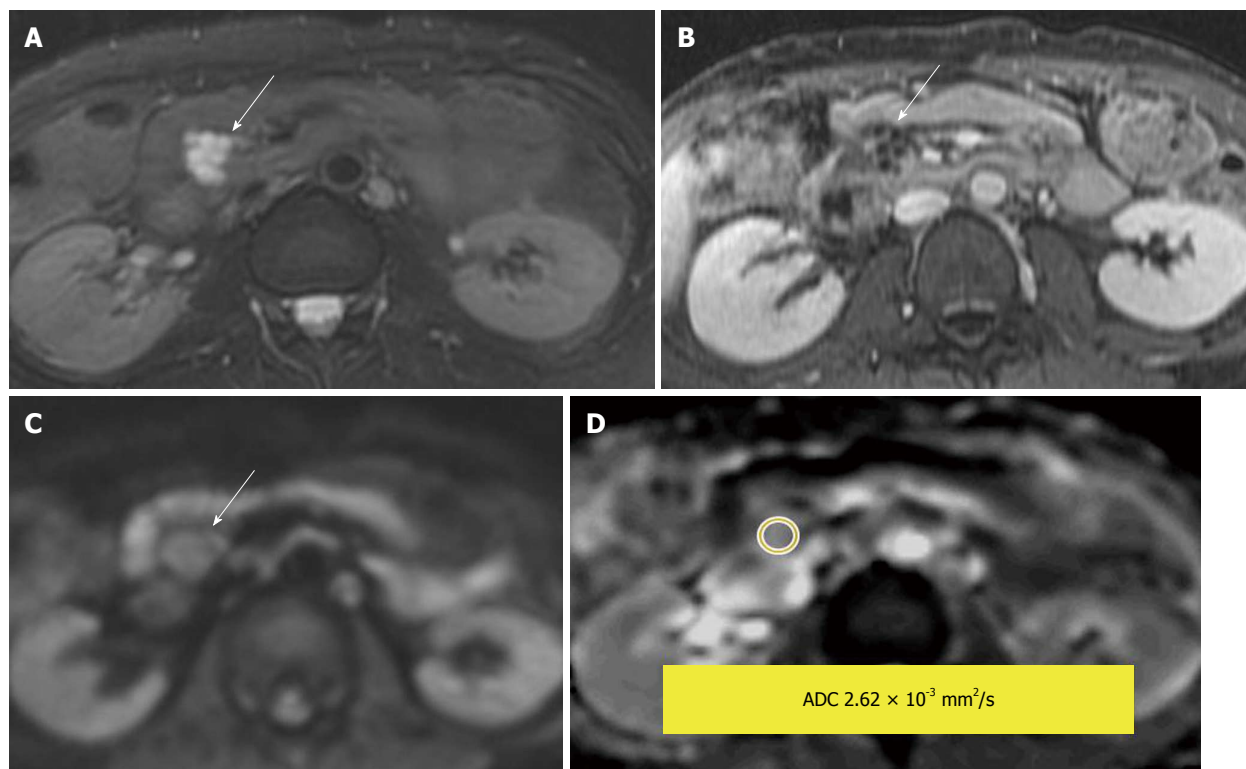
Side branch intraductal papillary mucinous neoplasms. A: Fat-saturated T2-weighted (T2W) Fast Spin-Echo; B: Post contrast T1-weighted gradient recalled-echo; C: Diffusion-weighted image; D: Apparent diffusion coefficient (ADC) map. A lobulated T2W hyperintense lesion with enhancement of the rim and internal septae. The measured lesion ADC = $2.62 \times 10^{-3} \text{ mm}^2/\text{s}$. The reference for fluid in this study (cerebrospinal fluid) was ADC = $3.36 \times 10^{-3} \text{ mm}^2/\text{s}$.
